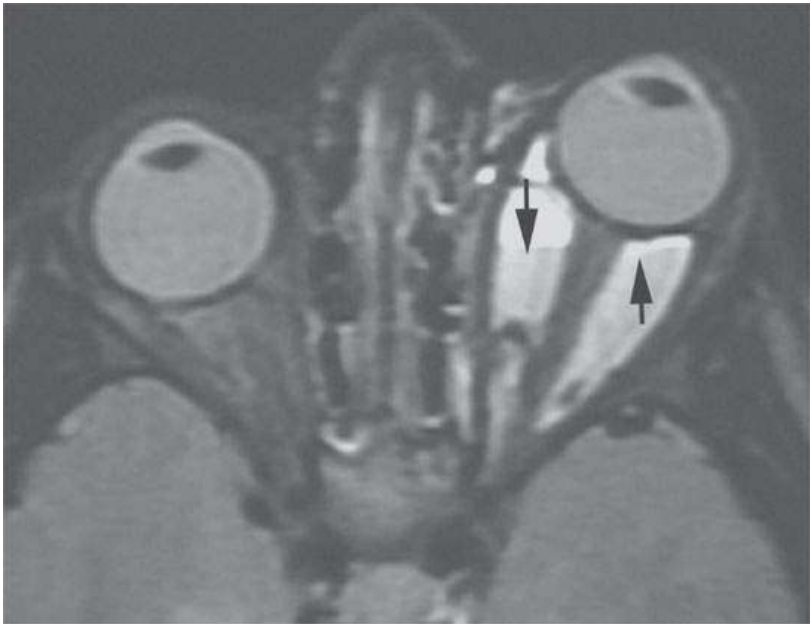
Short T1 inversion recovery (STIR) magnetic resonance image of a patient who presented with acute enlargement of an orbital mass. Fluid–fluid levels (*arrows*) are likely related to blood products.
